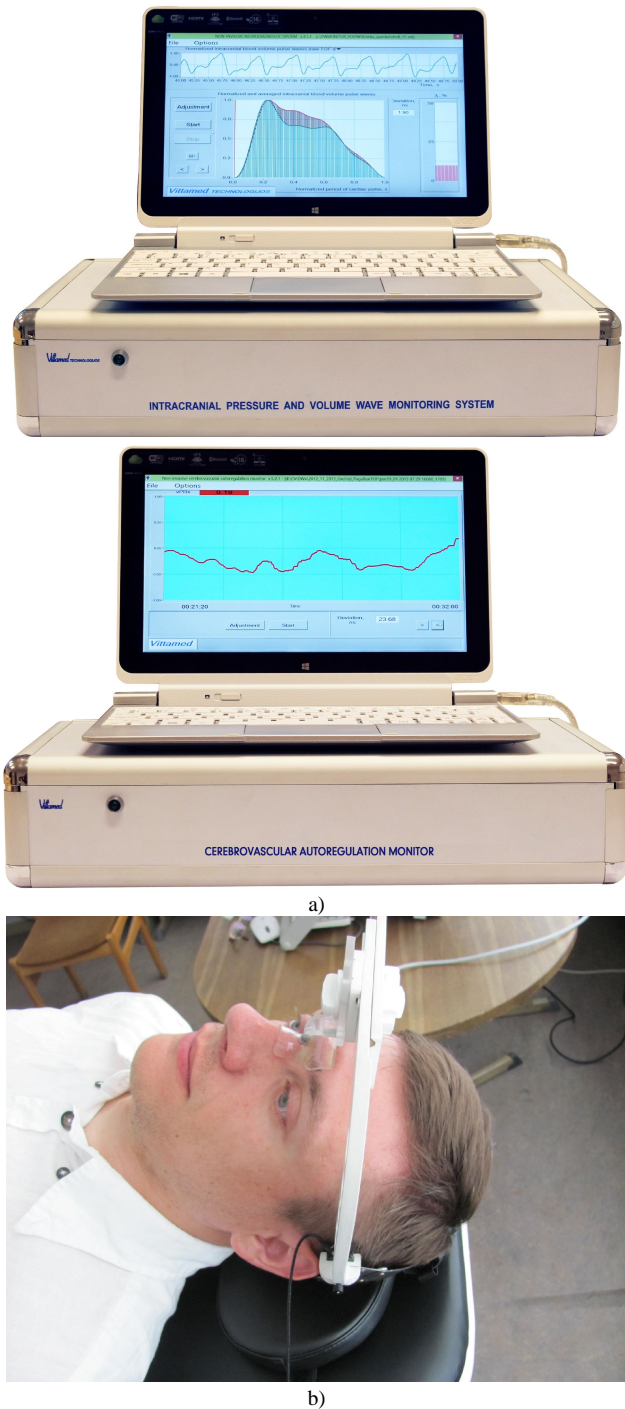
The non-invasive monitor for continuous real time monitoring of intracranial volumetric waves and cerebrovascular autoregulation (a) and also the mechanical frame mounted on the volunteer's head in order to fix the ultrasonic transducers in the position ensuring ultrasound wave transmission through the brain parenchyma (b).
